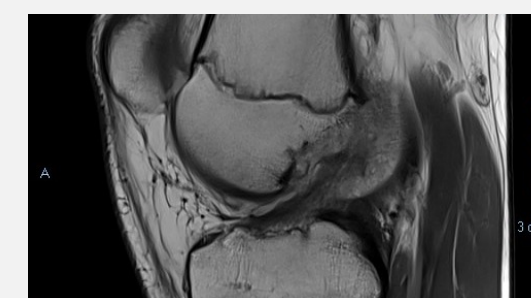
MRI taken 1 year post treatment
